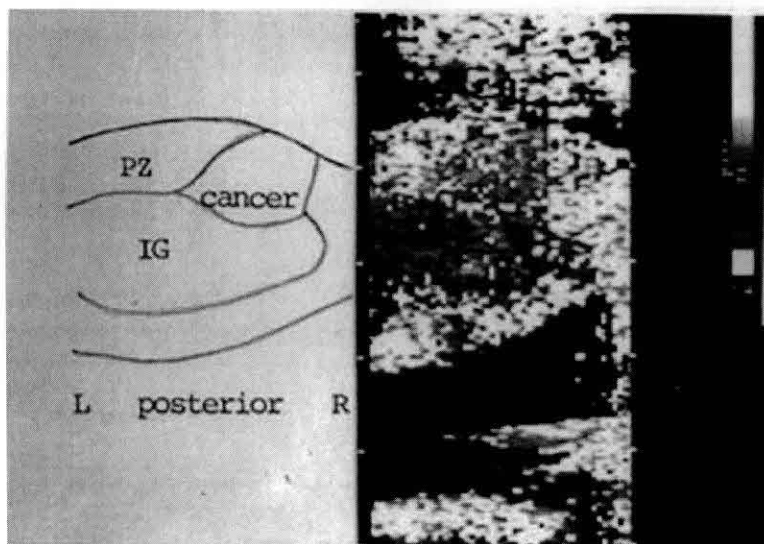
A representative first generation image of vibration sonoelastography, circa 1990. Doppler spectral variance is employed as an estimator of vibration in the 1-10 micron range and displayed over the B-scan images. No color implies low vibrations below threshold. Shown is the fill-in of vibration within a whole prostate, with a growing cancerous region indicated by the deficit of color within the peripheral zone. Courtesy of Dr. R. M. Lerner.
